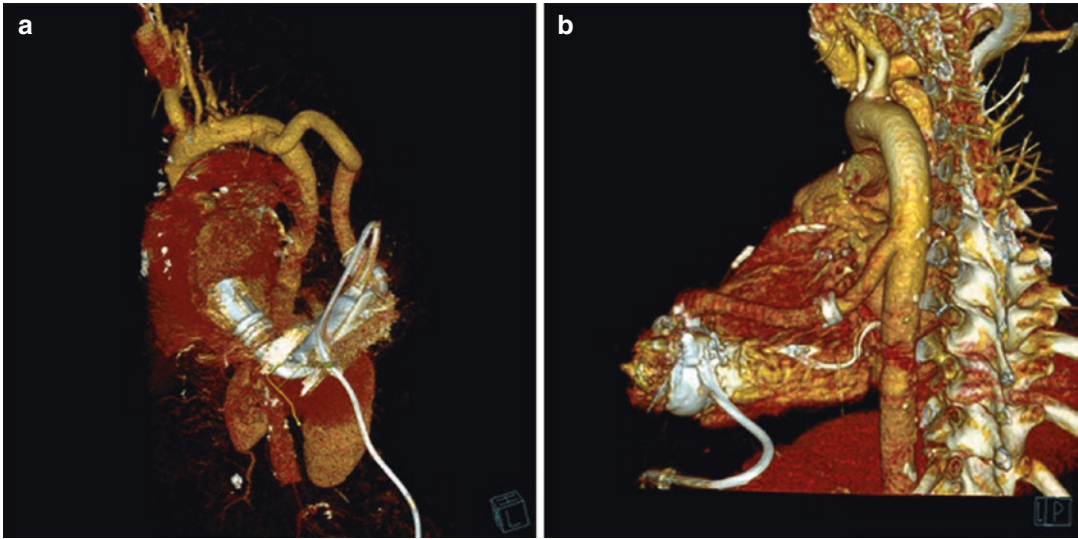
CT scan reconstruction of LVAD implanted via left lateral thoracotomy with outflow graft connection to descending aorta: (a) HeartMate II; (b) HeartWare
